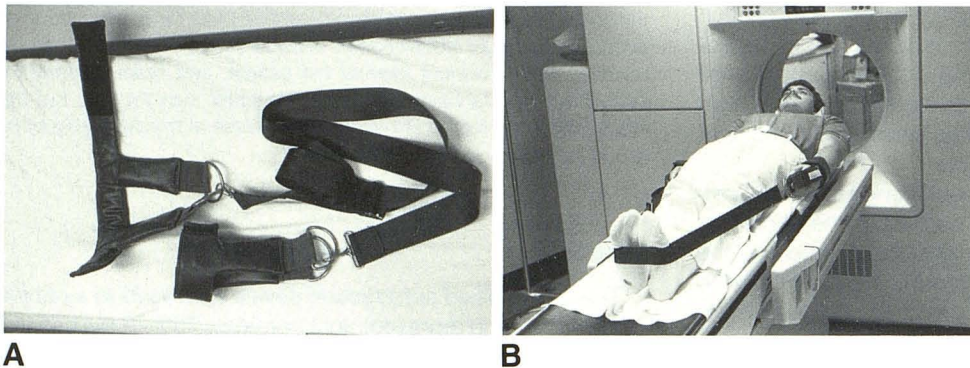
A, Configuration of CT-modified autotraction device. B, Technique of application.
